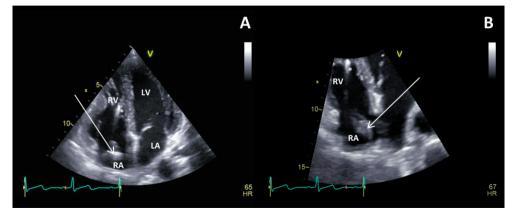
Transthoracic echocardiographic evaluation of a patient with lead endocarditis. Vegetation on the atrial lead (arrow). Right ventricular lead (asterisk).
